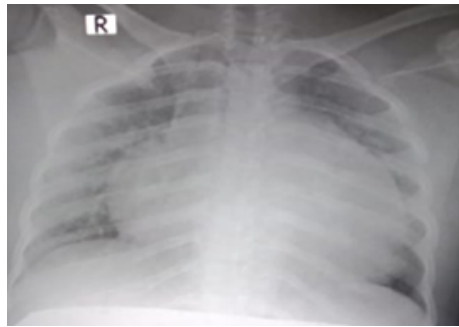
Chest radiograph AP view showing increased cardiothoracic ratio, straightening of left heart border, obliteration of right costophrenic angle and ground glass opacification of right lung field in middle and lower segments.
